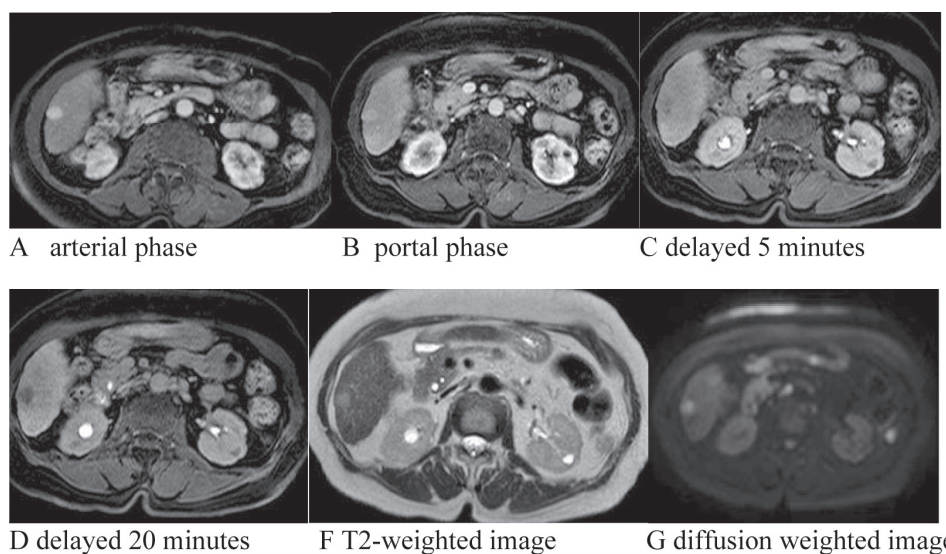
Axial imaged of gadoxedate -enhancement MRI in a 71- year-old woman with hepatitis B and hepatocellular carcinoma at segment 6. The liver mass at segment 6 measuring 1.5x1.4 cm in size showed hypersignal intensity on T2 weight (E), arterial phase (A) hyperenhancement, washout on portal phase (B) with enhancing capsule. The mass showed restriction (F) on DWI, hyposignal intensity on transitional phase (C) and delayed 20 minutes image (D). This hepatic observation was categorized as LR 5 according to LIRAD version 2018. HCC was confirmed with pathological report.
